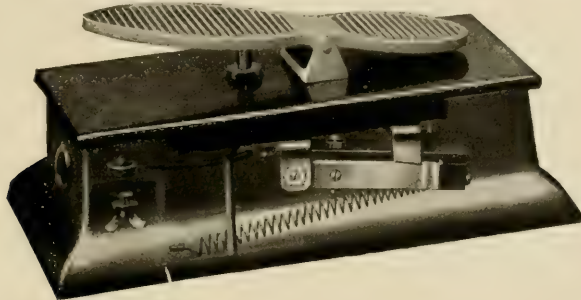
A foot-switch by means of which the operator may stand any desired distance from the X-ray machine and tube when the current is turned on.
